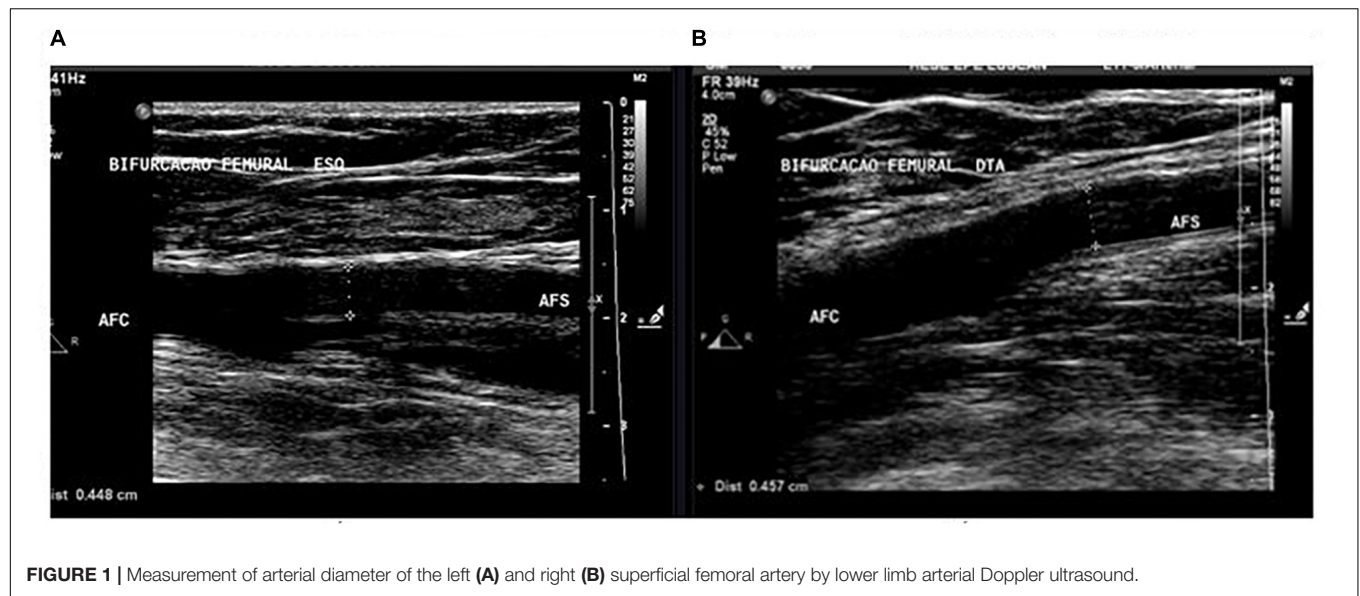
Measurement of arterial diameter of the left (A) and right (B) superficial femoral artery by lower limb arterial Doppler ultrasound.
